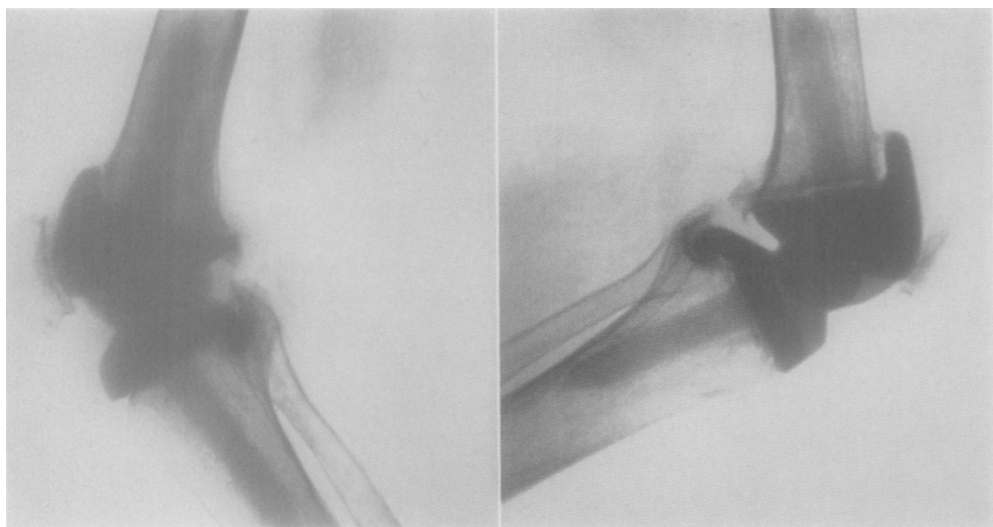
Case 24: roentgenogram of right knee 7 months after arthroplasty, and of left knee 10 months after arthroplasty.
